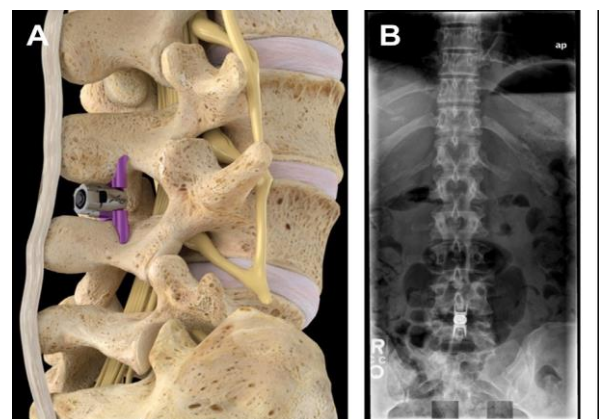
A. Percutaneous Interspinous Spacers Seen Laterally. B. Anteroposterior (AP) Radiography Image of the Interspinous Spacer's Final Location. (Figure supplied by Boston Scientific with permission) (16)
